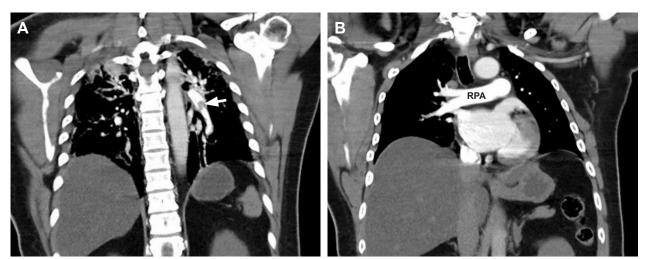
(A) Spiral computed tomography of pulmonary arteries showed filling defects (arrow) in the left lower lobar and segmental pulmonary artery that was comparable with left pulmonary artery embolism. (B) No obvious radiographic lesions were found in the right pulmonary artery (RPA).
